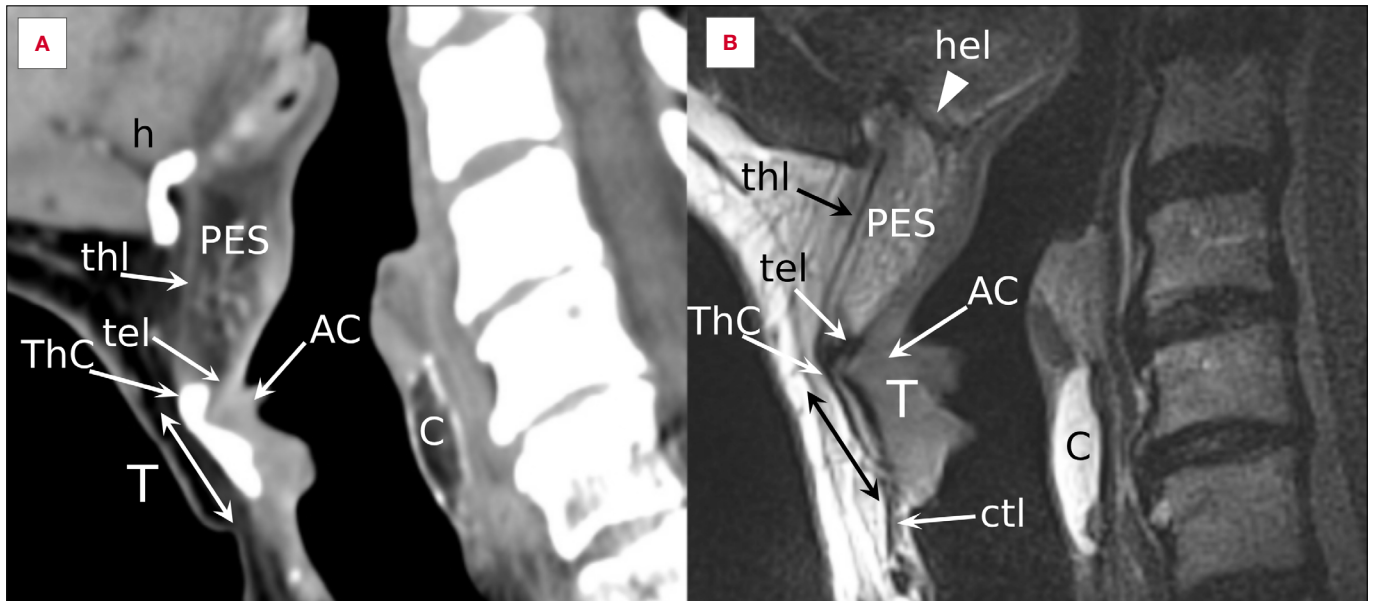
Comparison between sagittal CT (A) and MRI (B) of a cT2 of the AC with vertical extension to the subcommissural area. h: hyoid bone; PES: pre-epiglottic space; thl: thyro-hyoid ligament; tel: thyro-epiglottic ligament; hel: hyo-epiglottic ligament; ThC: thyroid cartilage; AC: anterior commissure; T: tumour (double arrows show its vertical extent); C: cricoid lamina; ctl: crico-thyroid ligament.
